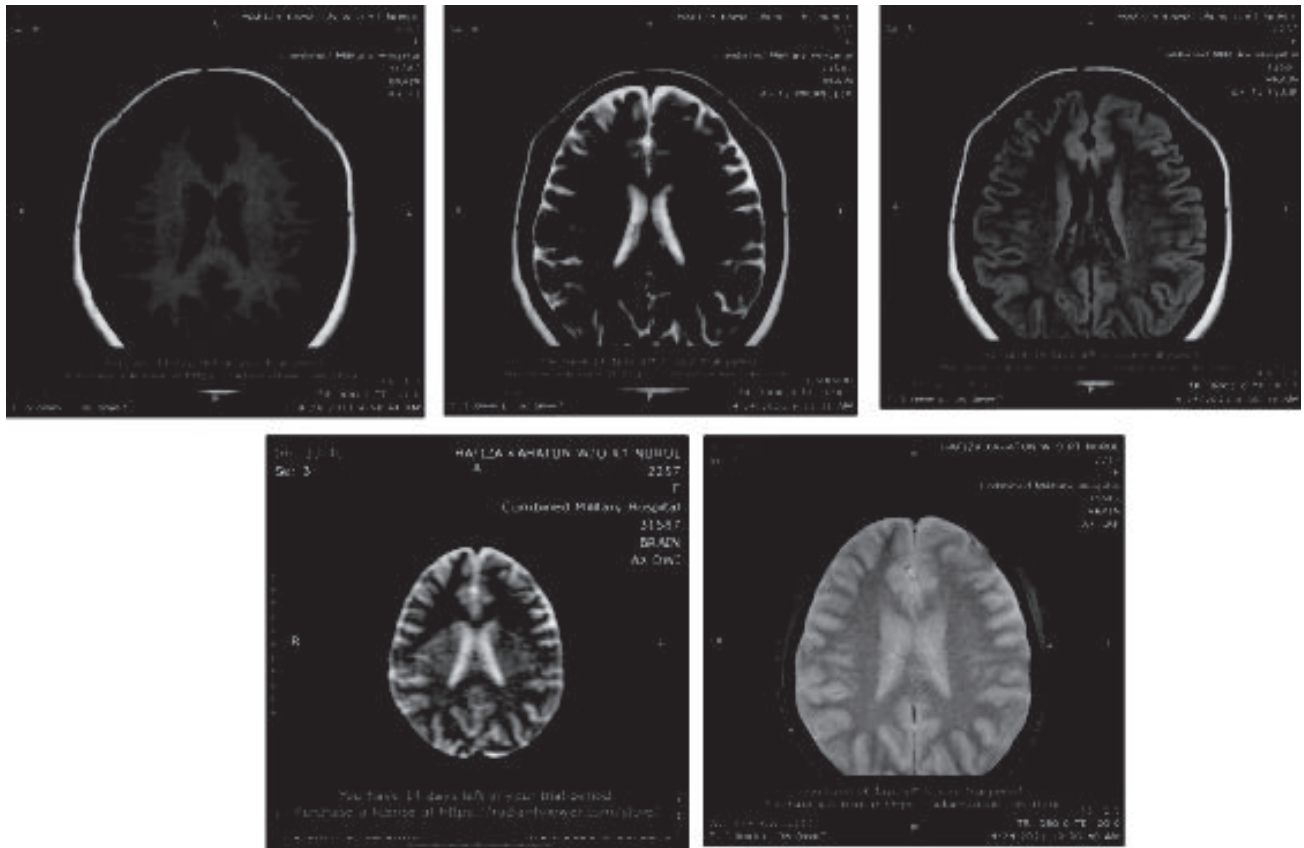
MRI of Brain was done on 24th April 2021
